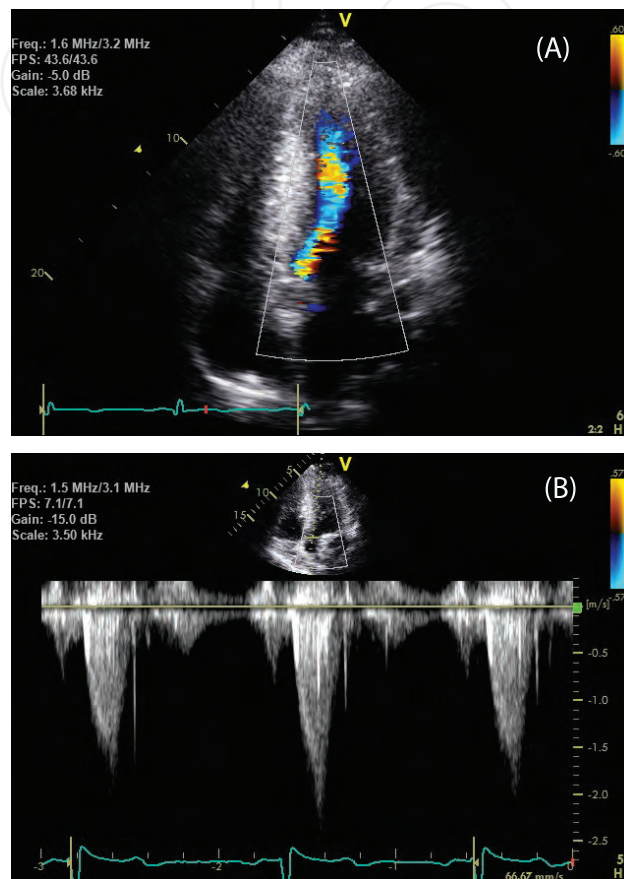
(A) Asymmetric septal hypertrophy may cause narrowing of the left ventricular outflow tract, resulting in turbulent flow. (B) Doppler analysis across the LVOT in dynamic obstructive HCM results in a characteristic signal with a late-peaking dagger-shaped appearance.
